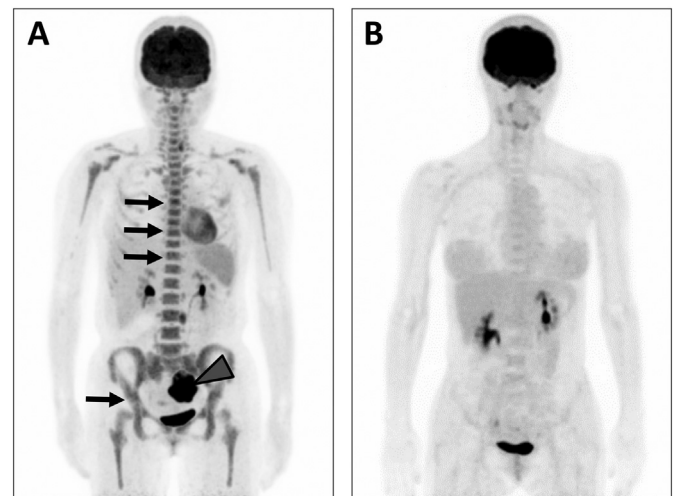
Result of ¹⁸F-FDG-PET/CT. A: The present case. B: An age-matched healthy female. The present case showed the strong accumulation of FDG in the left ovarian tumor (the gray arrowhead) and systemic bone marrow (black arrows).
